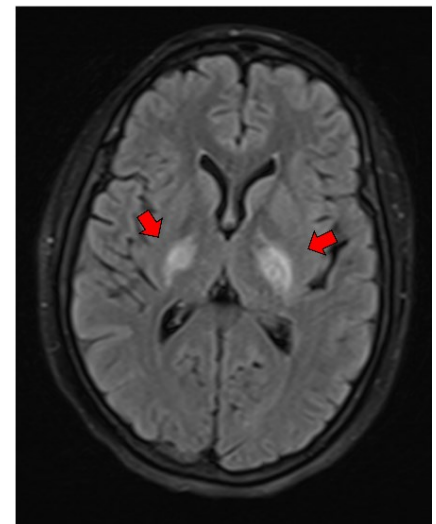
Basal ganglia lesions on FLAIR sequence in axial plane
